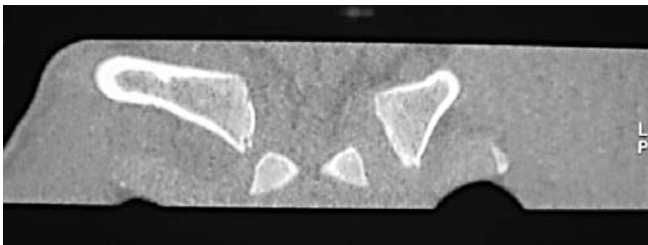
CT-scan of the induced anterior subluxation of the right sternoclavicular joint
